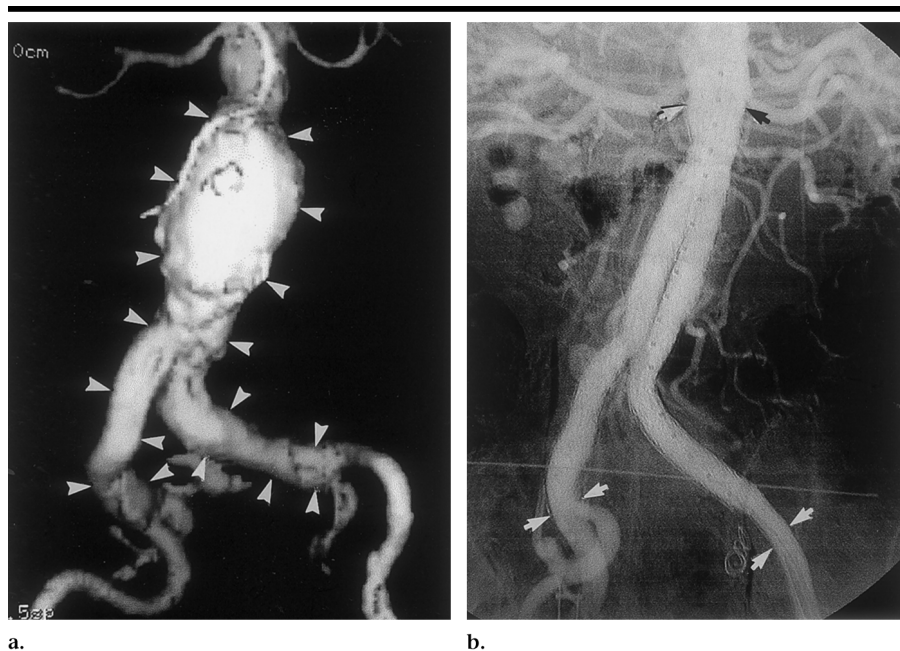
Enlarging abdominal aortic and bilateral iliac artery aneurysms. (a) Anterior view of a three-dimensional shaded-surface display of a pretreatment contrast agent-enhanced CT scan delineates the aneurysms (arrowheads). (b) Posteroanterior aortogram obtained after placement of a bifurcated endograft (Excluder; W. L. Gore & Associates, Flagstaff, Ariz) and embolization of the left iliac artery with Gianturco coils (Cook, Bloomington, Ind). Arrows delineate upper (aortic) end and lower (iliac) ends of the endograft. Note that there is no flow seen outside of the endograft within the aortic aneurysm (ie, no endoleak), the upper end of the graft is well positioned in the upper aortic “neck” just below the renal arteries, and the embolization coils in the left internal iliac artery trunk are seen just below and medial to the left distal endograft attachment. Although the right internal iliac artery is patent and provides flow across the pelvis (depicted on later arteriographic frames, not shown), the coils prevent retrograde filling of aneurysms.
